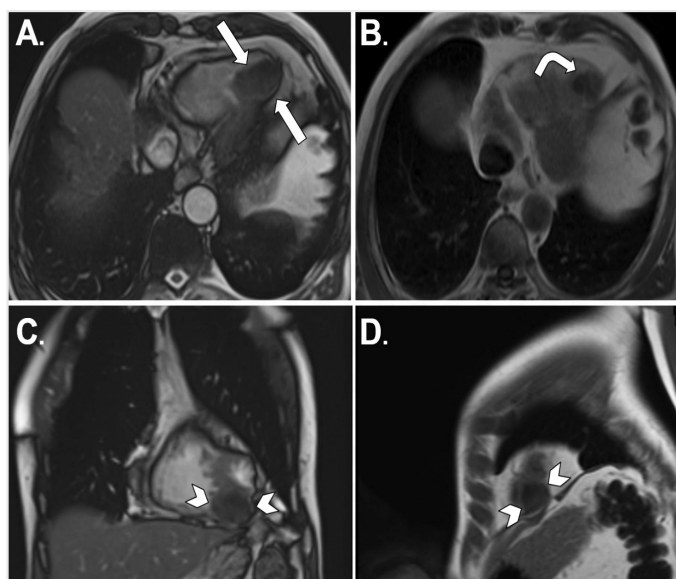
(Patient 22*) The cyst is hypointense on precontrast axial T1-weighted image (arrows, A) and heterogeneous and hypointense on precontrast axial (curved arrow, B) and coronal T2-weighted image (arrowheads, C). On sagittal T1-weighted, delayed-phase cardiac images after contrast injection, peripheral rim enhancement (arrowheads, D) is seen around the cyst
